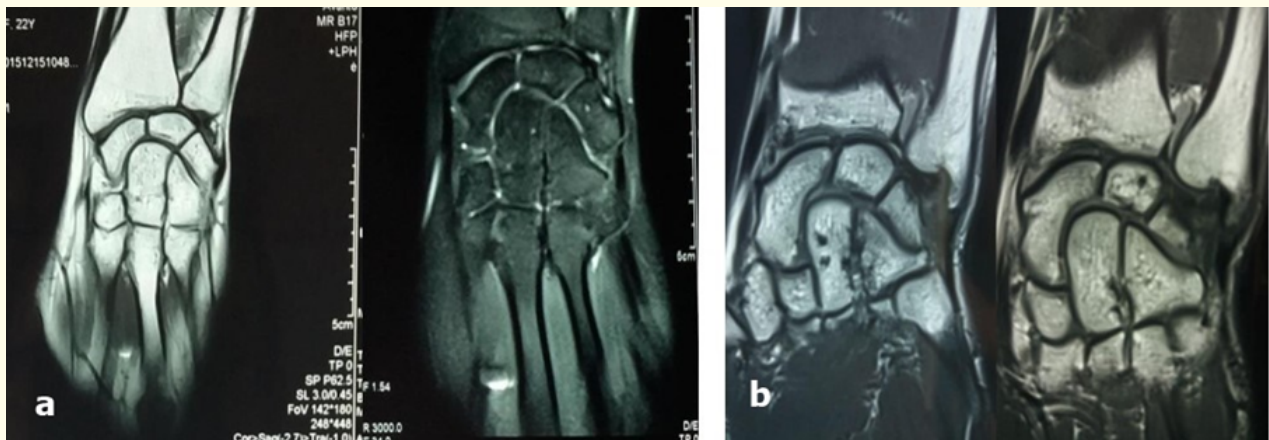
MRI images of two cases showing TFCC lesions type.
